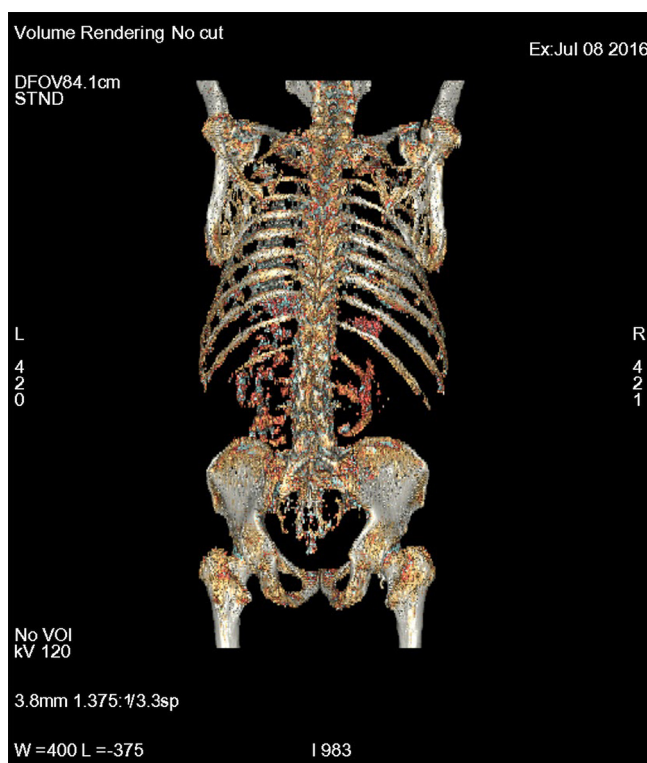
Recent 18-FDG-PET/CT (Volume rendering) showing no lesions in ribs or spine. FDG: fluorodeoxyglucose; PET: position emission tomography; CT: computed tomography
